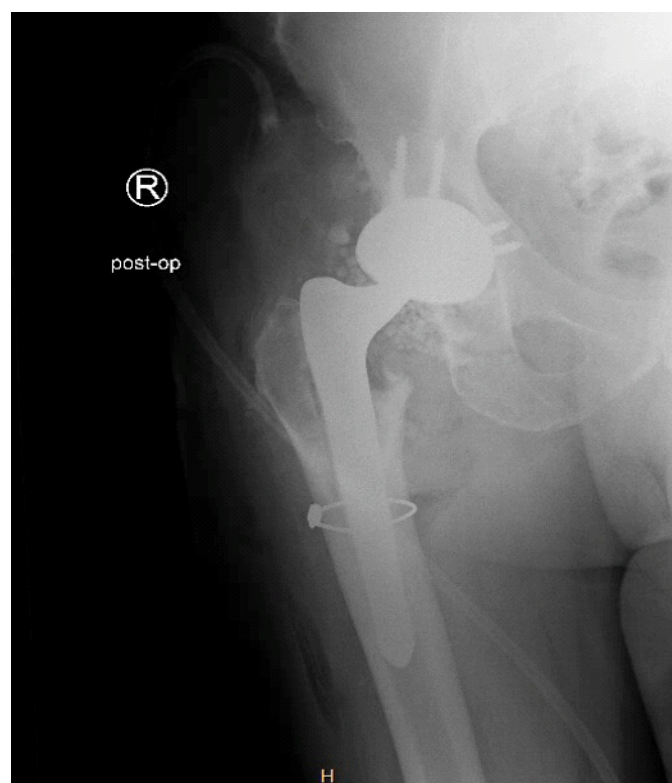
Post-operative radiograph after second-stage definitive THA. Post-operative AP radiograph demonstrating definitive implant including revision multi-hole acetabular component, cerclage cable, and a monoblock diaphyseal engaging stem.
